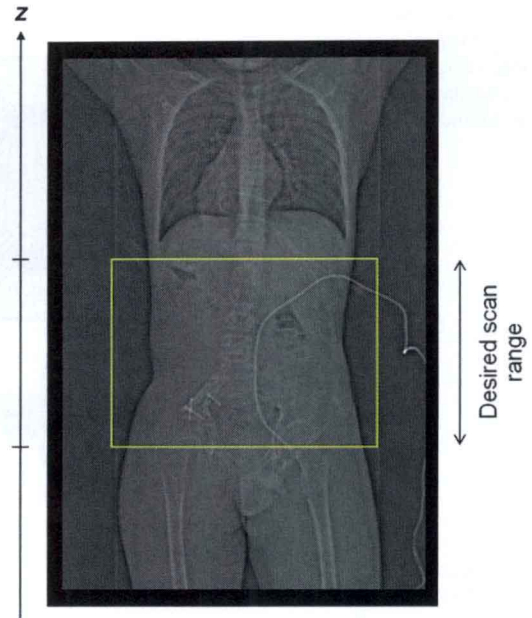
The topogram is a digitally enhanced version of a radiographic projection used to graphically select the desired scan range
